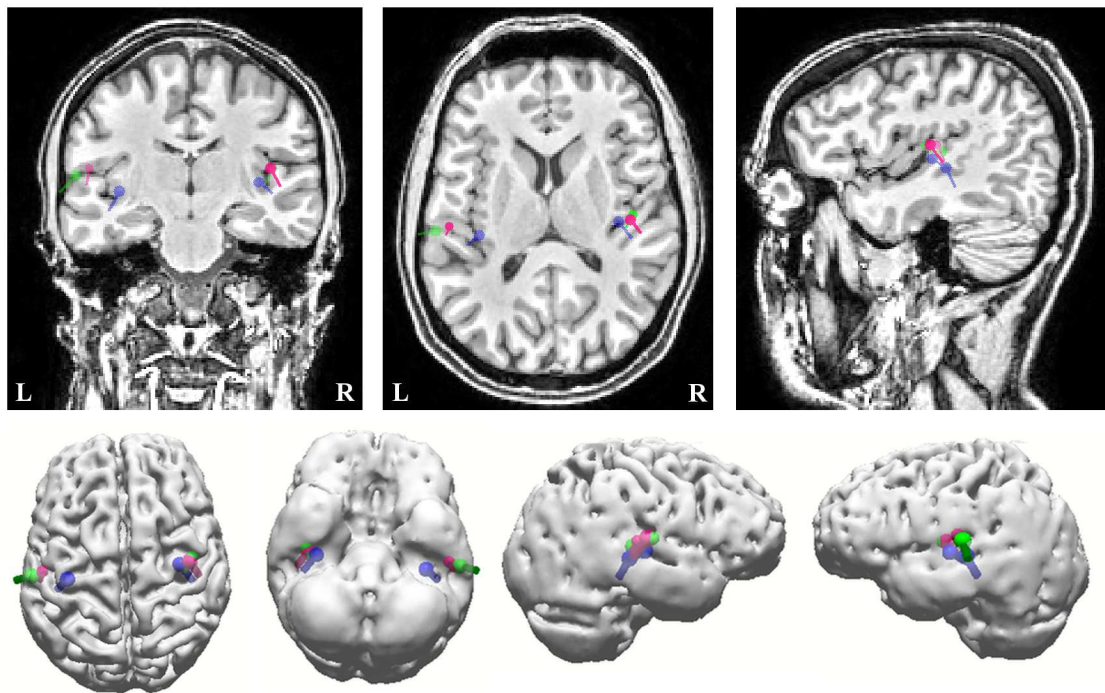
The EEG (blue dipoles), MEG (green dipoles) and EMEG (red dipoles) source reconstructions for the rising flank of the N100(m) component for the stimulation with 1000 Hz are shown on the MRI (upper figures) and on a volume rendering of the brain (lower figures).
